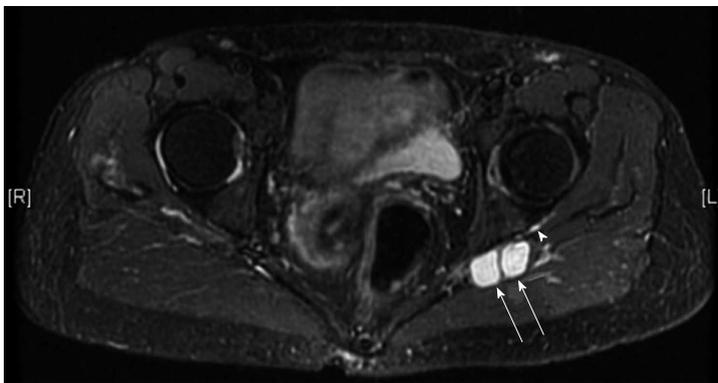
A 67-year-old female with a sciatica. Axial short tau inversion recovery magnetic resonance image demonstrates cysts at the posterior aspect of the left acetabulum (arrows). The stalk is connected to the posterior joint capsule (arrowhead).
